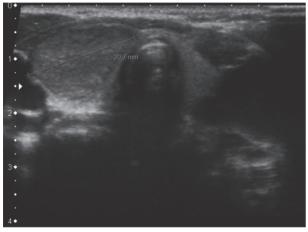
Cervical ultrasound: hyperechogenic solid nodule with 23 x 11 x 20 mm at the thyroid right lobe, with a hypoechogenic halo.
